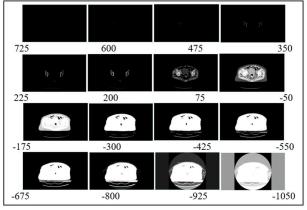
CT-scan distance scale
